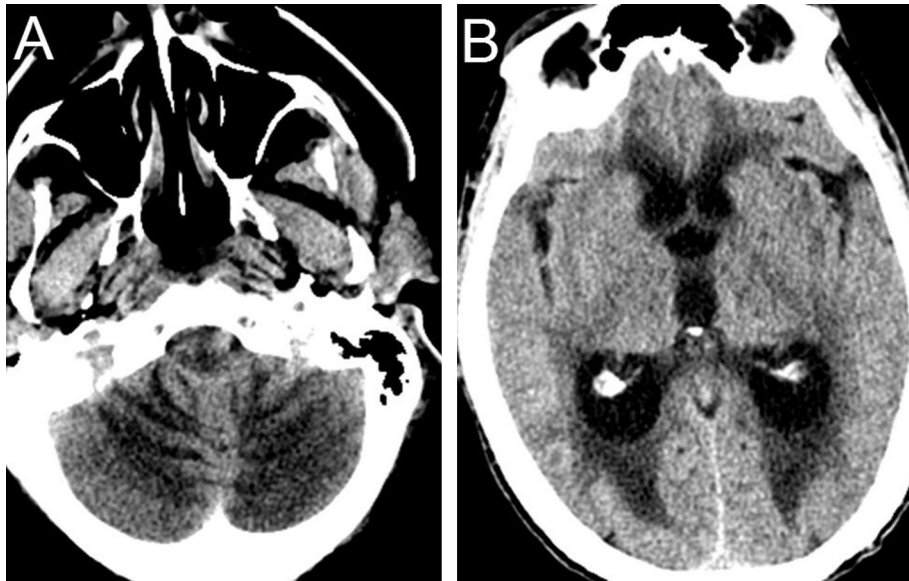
Pre-operative non-contrast axial head CT scan showing (A) cerebellar edema, effacement of fourth ventricle and basilar cisterns, and compression of the brainstem, and (B) dilated lateral ventricles with transependymal flow.
